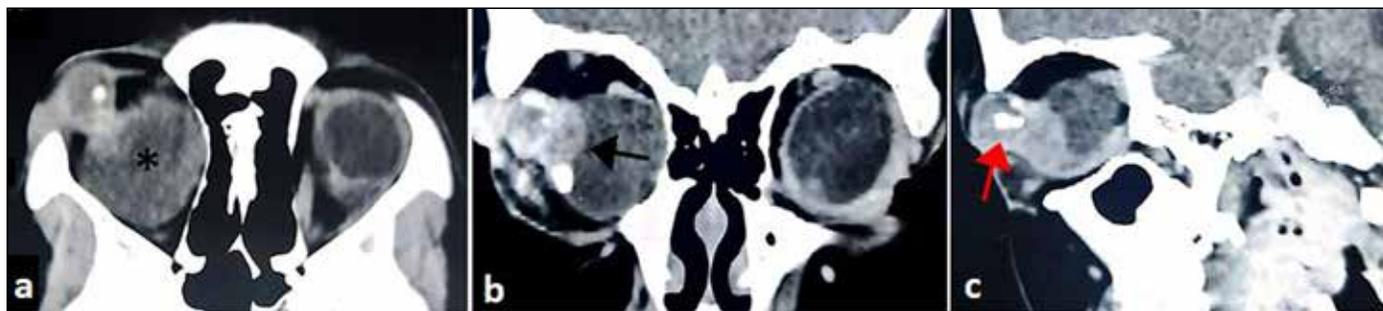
Orbital Computed tomography (CT) scan of the right eye (a) Axial view showing a well-defined cystic lesion (asterisk) located in the retro-orbital plane. (b) Coronal view showing presence of a solid component (black arrow) within the lesion with calcifications (c) Sagittal view demonstrating enhancement of the calcifications (red arrow) within the shrunken globe.
